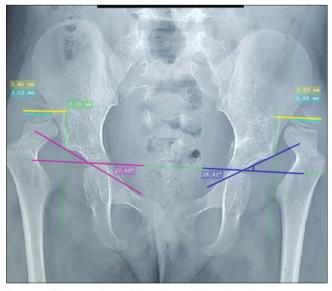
Pre-operative pelvic radiograph in patient 3
